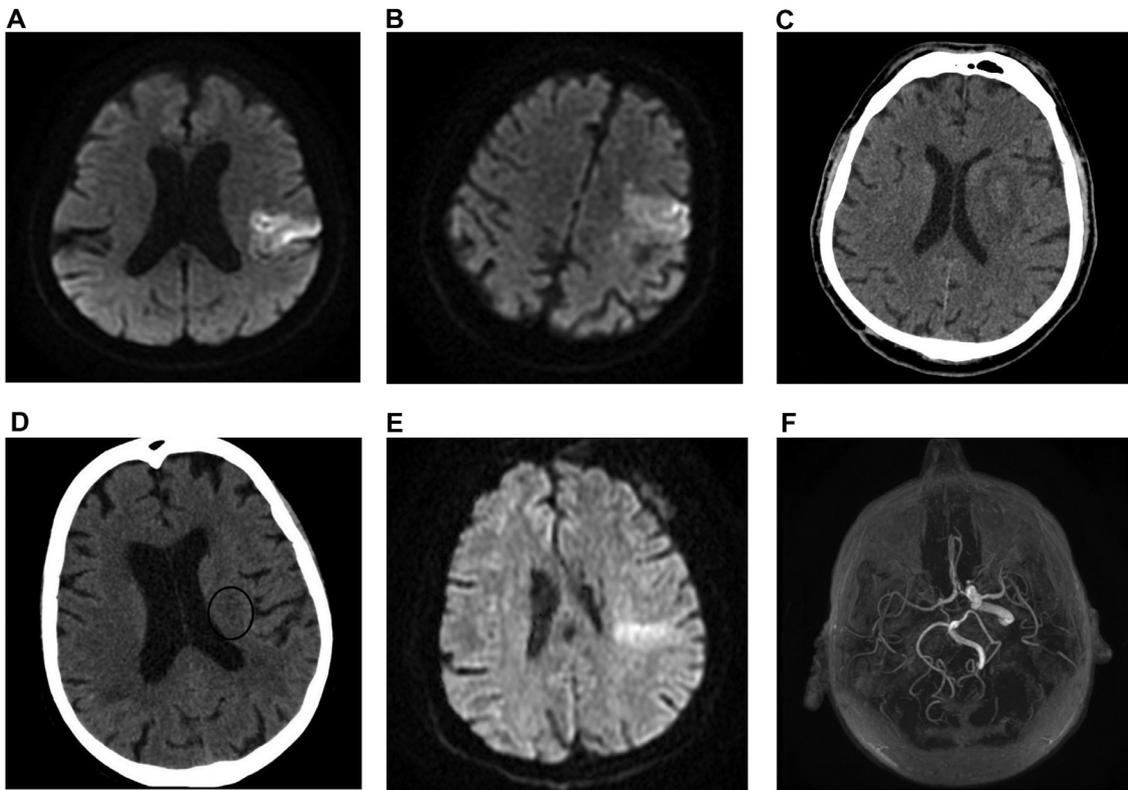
CT and MRI scans of patients approximately 24 hours after thrombolysis. (A) Diffusion-weighted imaging (DWI) scan of Patient 1, showing left MCA territory cortical ischaemia. (B) DWI scan of Patient 2 shows a similar brain infarct. (C) Noncontrast CT (NCCT) scan of Patient 3 after thrombectomy. The infarct mainly involves the left basal ganglia and internal capsule. (D) NCCT of Patient 4 showing slight hypodensity in the left corona radiata (striatocapsular infarct). (E) DWI scan of patient 5 shows a left MCA territory infarct. (F) MRA-TOF reconstruction of Patient 5 demonstrating enlarged left ICA and MCA. Abbreviations: MRA-TOF, MR angiography – time of flight; MCA, middle cerebral artery.
